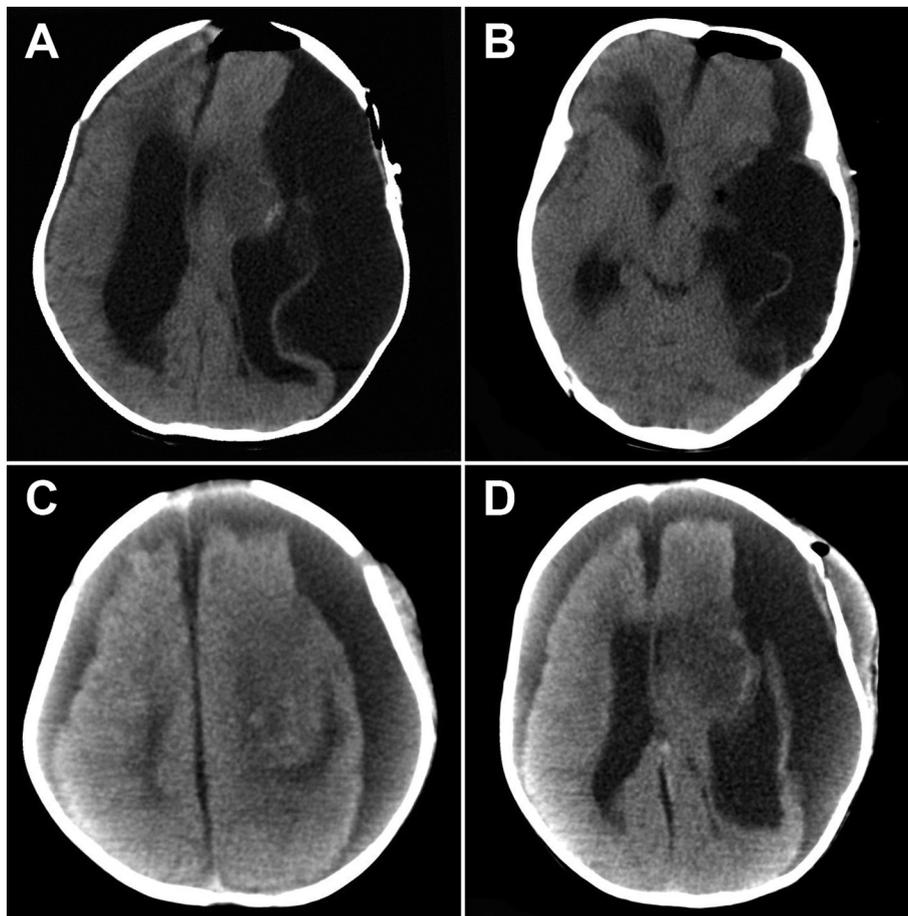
A–D are post-operative CT scans showing accumulation of fluid at the left frontal and temporal regions with compression on left parenchymal hemisphere.
